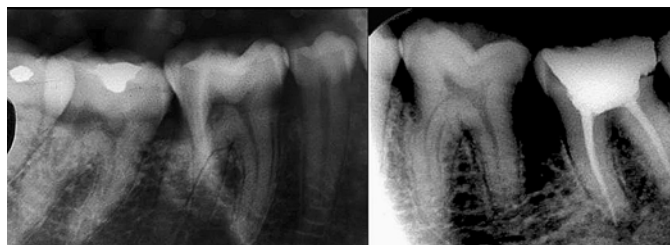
(Left) Radiograph showing the presence of a radix entomolaris on the mandibular right first molar. (Right) Radiograph of the mandibular left first molar showing no extra root. Case is a 36 year old male.
